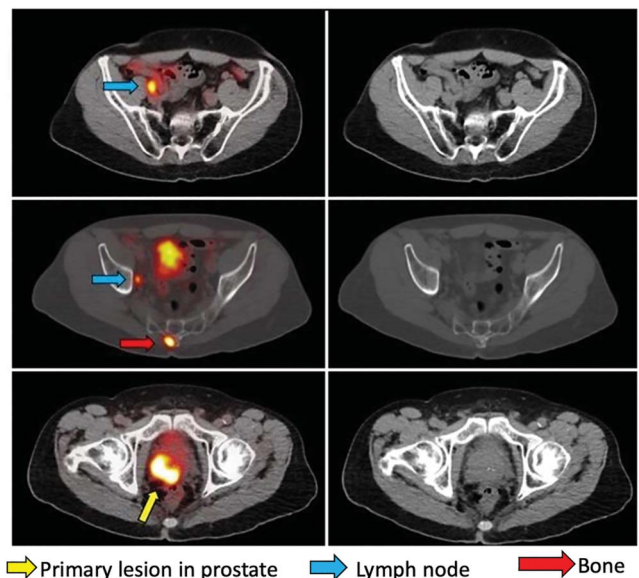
⁶⁸Ga-PSMA PET/CT scan (left) and corresponding CT scan (right) obtained for primary staging in a 77-year-old patient presenting with PSA of 7.1 ng/ml and prostate biopsy showing Gleason score of 4+5=9. Note clarity of cancerous lesions on PET/CT scan. PSMA expression is seen in the primary tumor (yellow arrow), lymph nodes (blue arrows) and in bone (sacrum, red arrow). NCCN Guidelines for 2021 have included PSMA PET/CT scanning for initial staging and to detect recurrence after primary treatment.¹
